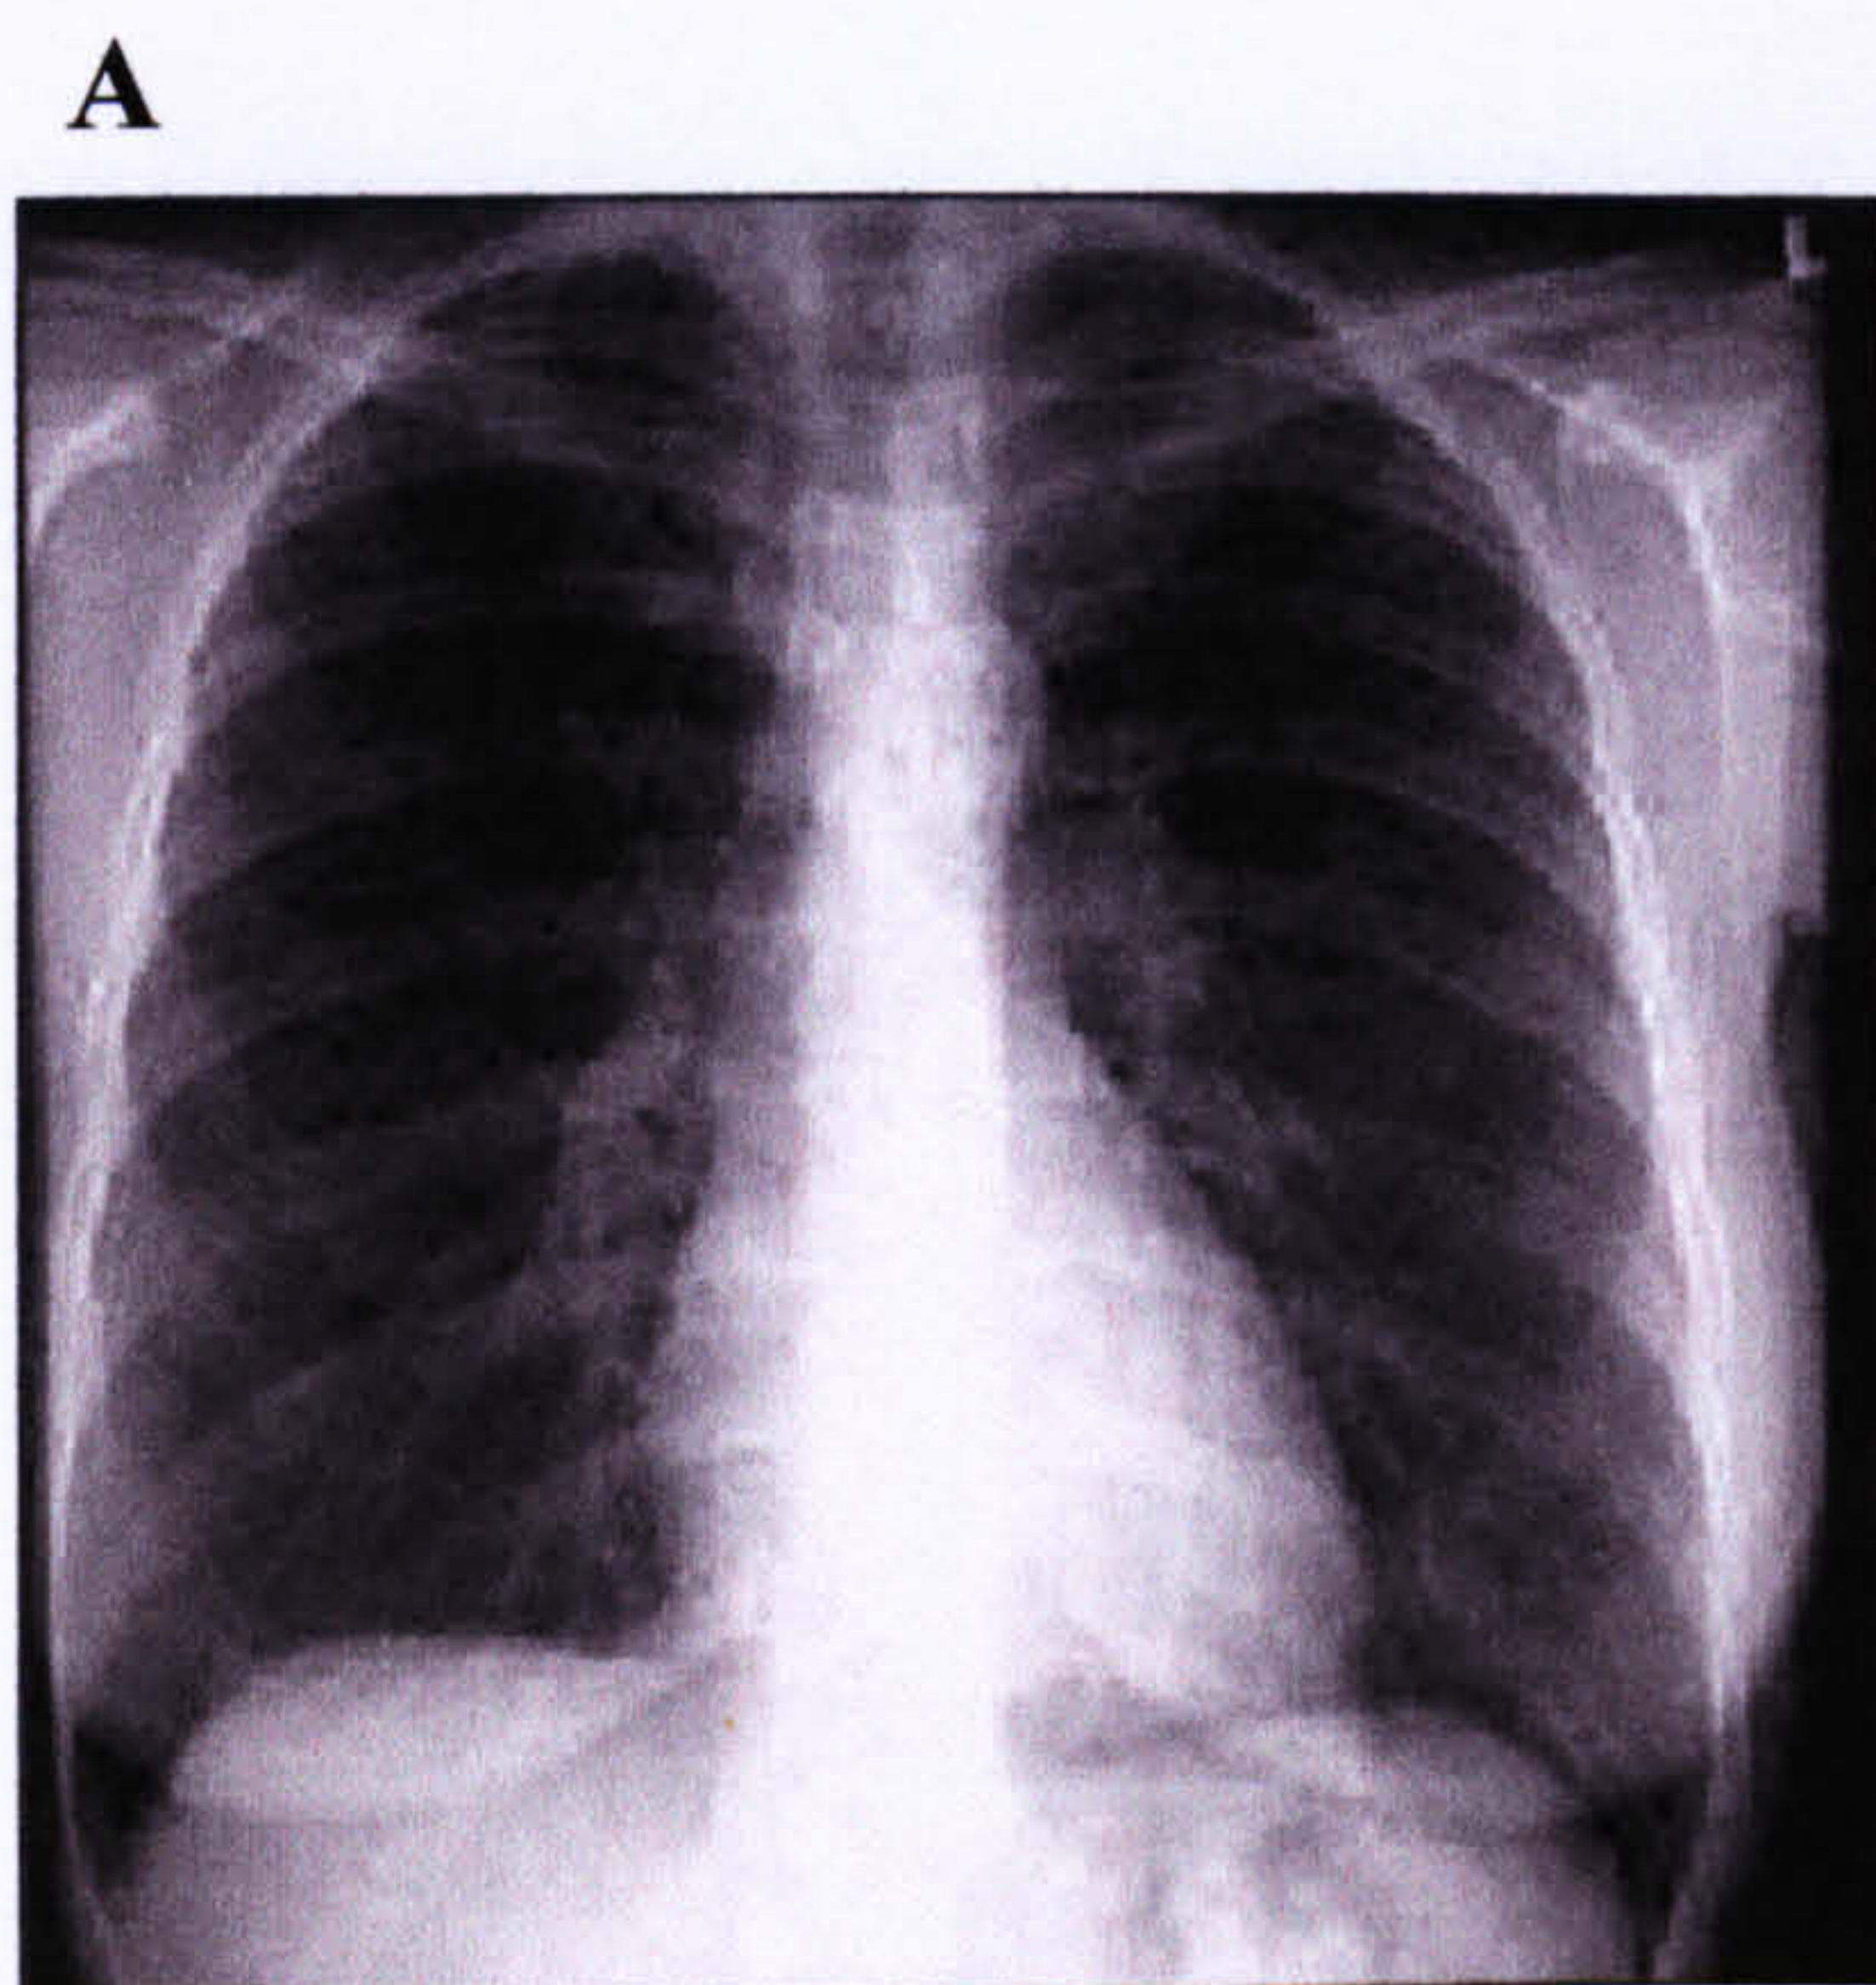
A. Normal Chest X-ray. B. Chest X-ray of complicated silicosis, taken from a Welsh lead miner with heavy exposure to silica dust. (From Morgan and Seaton, Occupational lung diseases.) On the X-ray, radio-opaque nodules are apparent as white areas, some confluent.*
